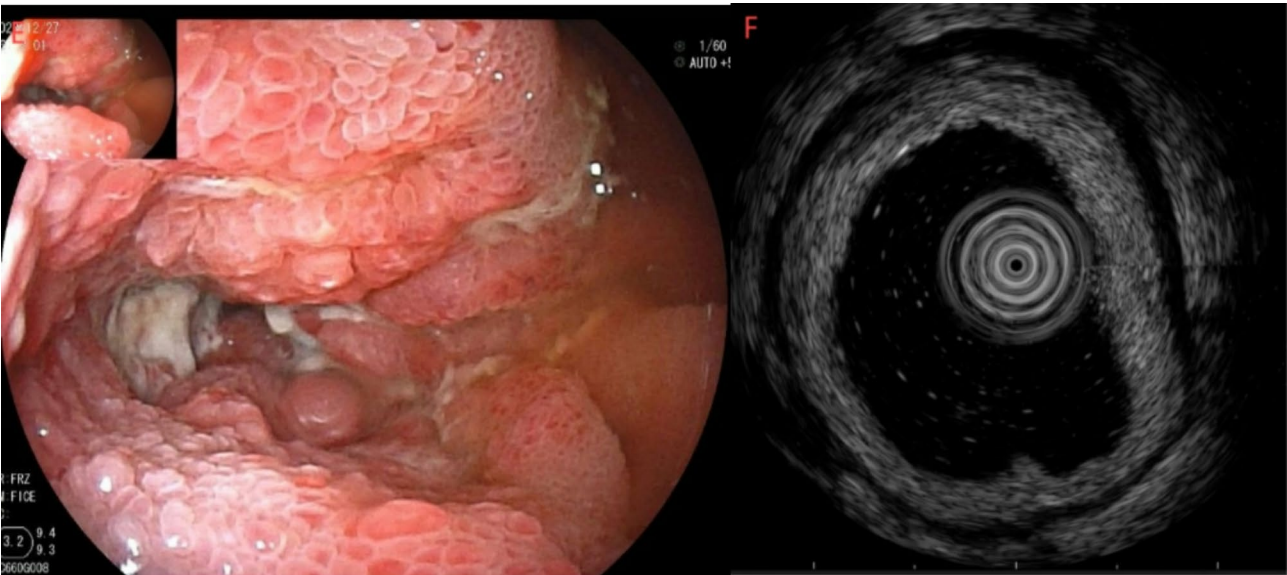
E: Endoscopic findings showing a stenosis of approximately 0.3 cm in diameter, with irregular ulcers around the stenosis. The ulcer surface is white coated, indicating severe disease activity. F: Small intestinal endoscopic ultrasound showing poor intestinal layer differentiation and significant thickening of the intestinal wall
